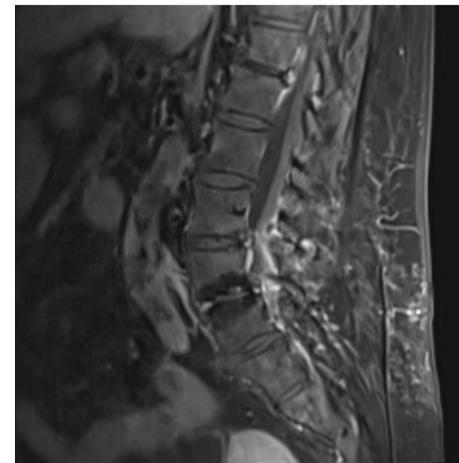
Disc space narrowing with edema and abnormal enhancement at the L4-L5 intervertebral disc, seen via magnetic resonance imaging.
